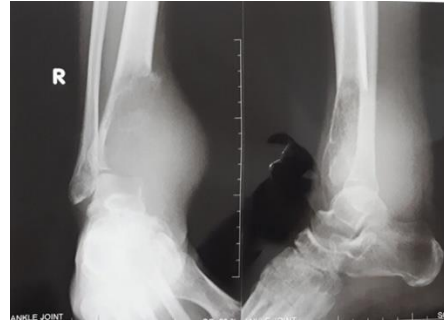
Plain Radiograph showed lytic lesion of meta-epiphysis of the distal tibia, geographic type, with cortical destruction, and thinning of the anterior cortex of distal tibia, suggestive for giant cell tumor
